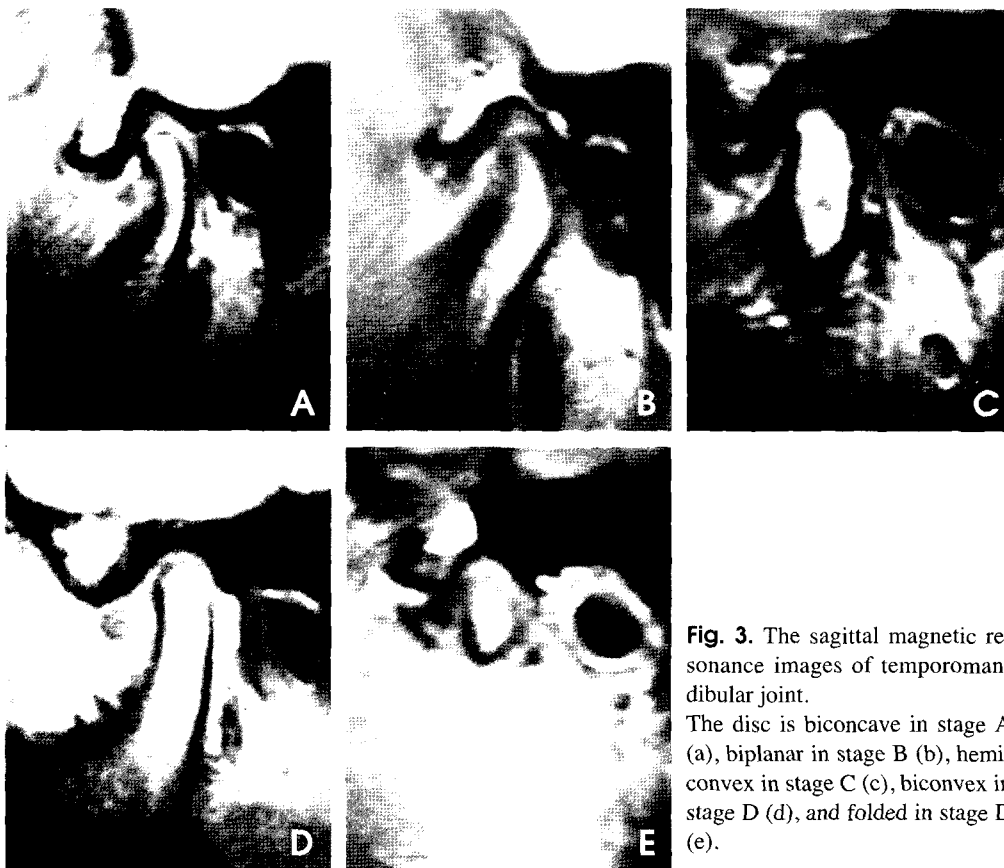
The sagittal magnetic resonance images of temporomandibular joint. The disc is biconcave in stage A (a), biplanar in stage B (b), hemiconvex in stage C (c), biconvex in stage D (d), and folded in stage D (e).
